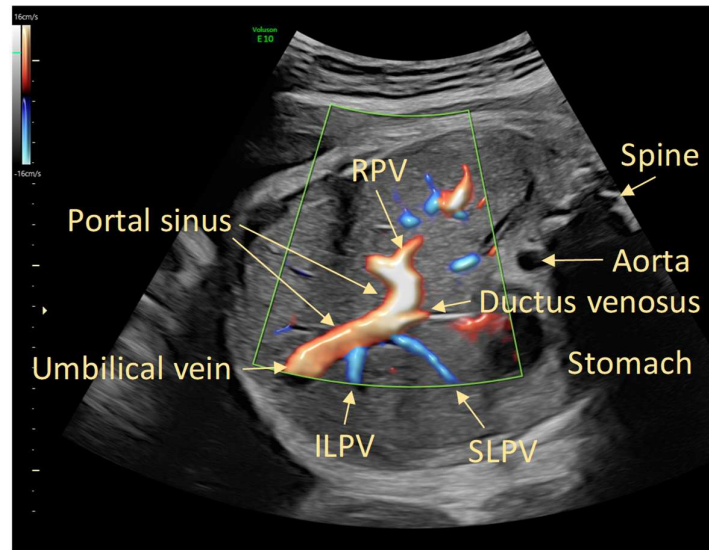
Ductus venosus imaged with contemporary ultrasound equipment in a transverse oblique section of the fetal abdomen. The ductus venosus is identified by colour flow mapping as a short vessel arising from the portal sinus opposite the umbilical vein enabling optimal positioning of the Doppler sample gate. ILPV inferior left portal vein, SLPV superior left portal vein, RPV right portal vein. Image produced by D Paoletti.
